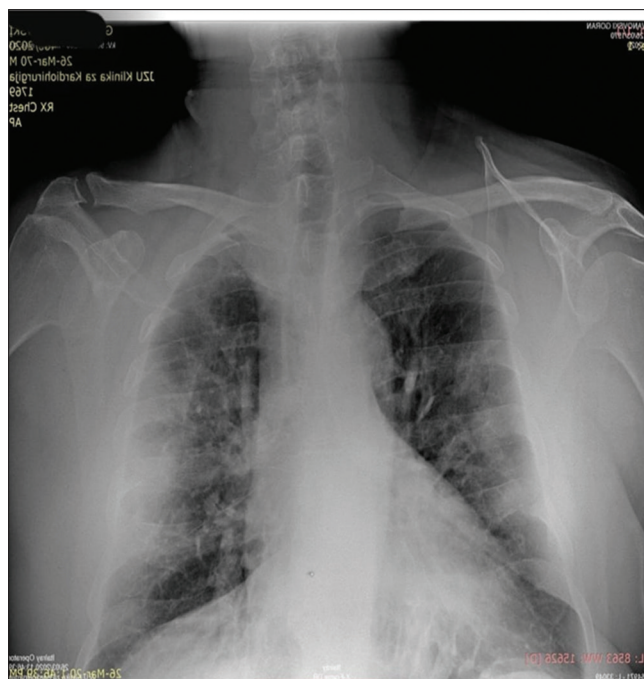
Bilateral pneumonia (chest X-ray on the 3rd day)
